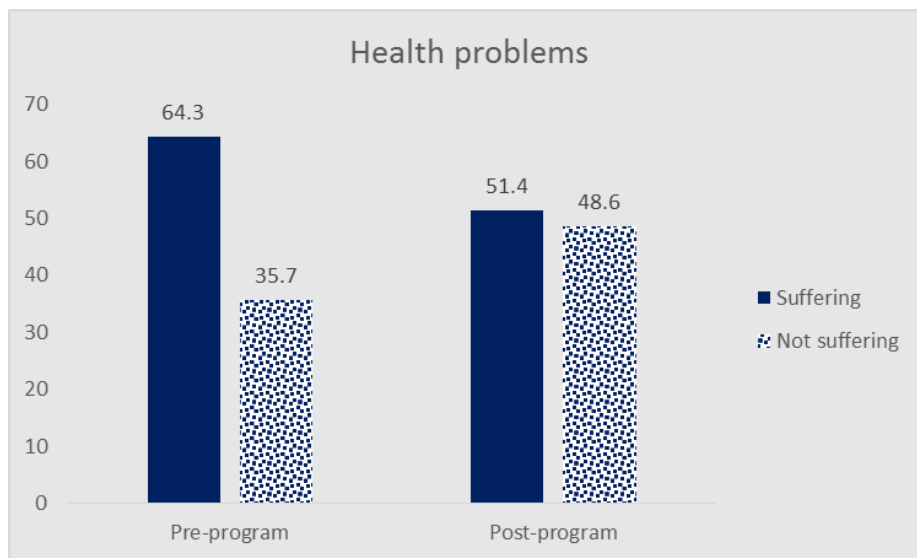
Distribution of studied radiographers regarding their suffering of health problems pre and post program implementation (n=70)
